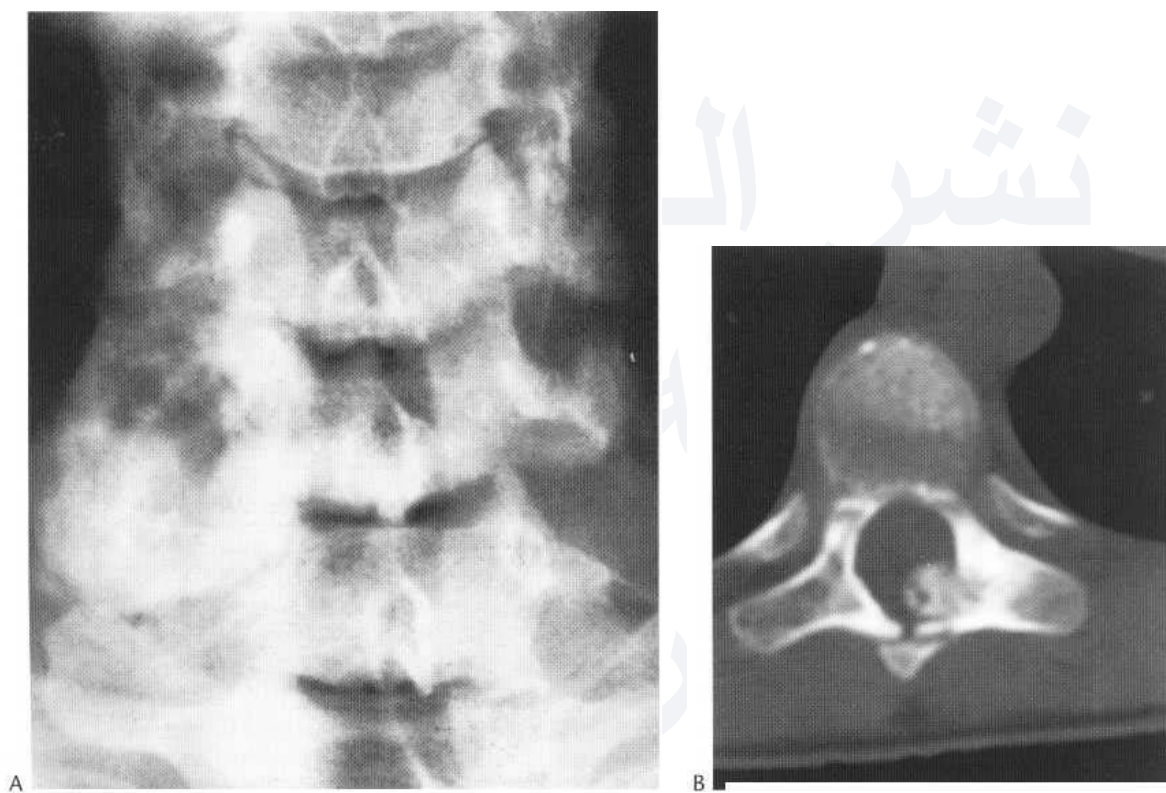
(A) Osteoblastoma of cervical spine. The right pedicle and lateral mass of the sixth cervical vertebra are enlarged and sclerotic, with an irregular central low-density nidus. (B) Osteoid osteoma. CT scan of mid-thoracic spine. There is sclerosis with focal expansion involving the left lamina. The tumour encroaches on the epidural space and contains a small nidus which is of low density.
